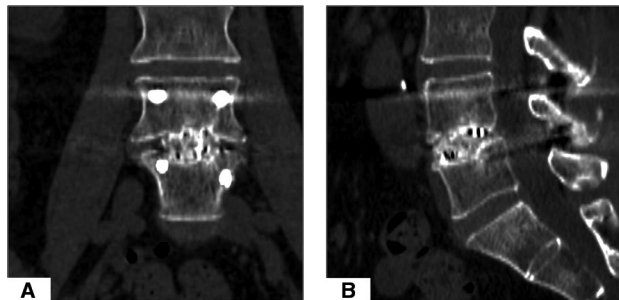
CT scan for three months after surgery. (A) Coronal scanning. (B) Sagittal scanning.
